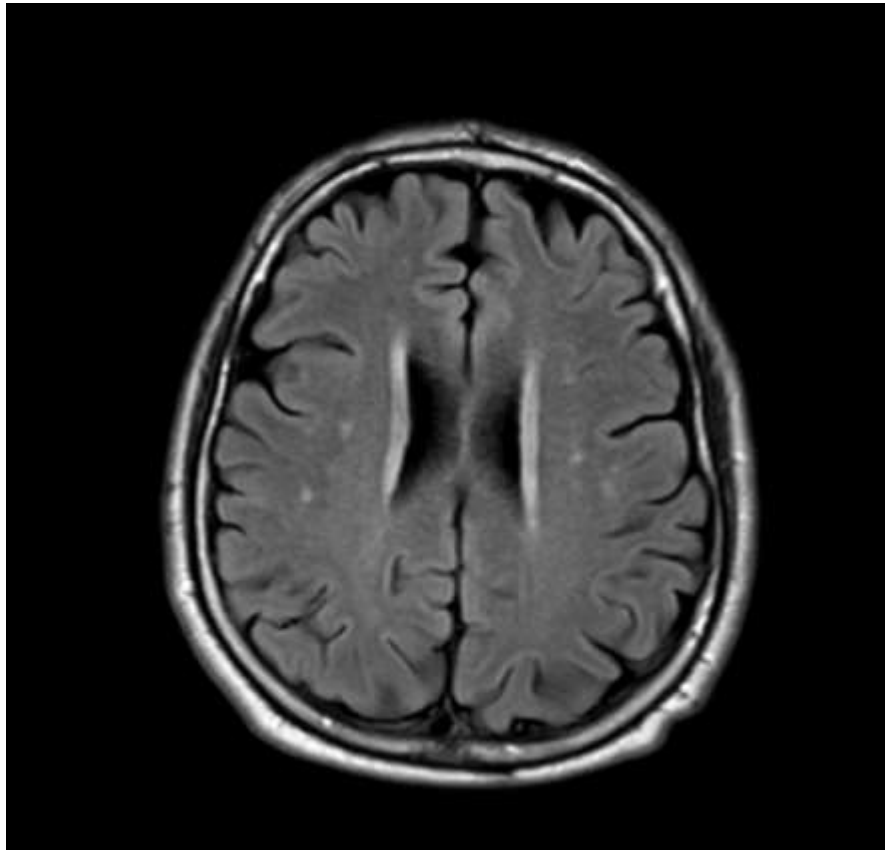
Axial MRI FLAIR-long TR image for patient number 1 shows mild microvascular disease. Small-vessel disease progression on brain MRI, the image shows pencil-thin lining on white-matter lesions at baseline. Large confluence extended into deep white-matter lesions at. And shows a punctate white-matter lesion at baseline, and a confluent white-matter lesion appeared on the same regions.
